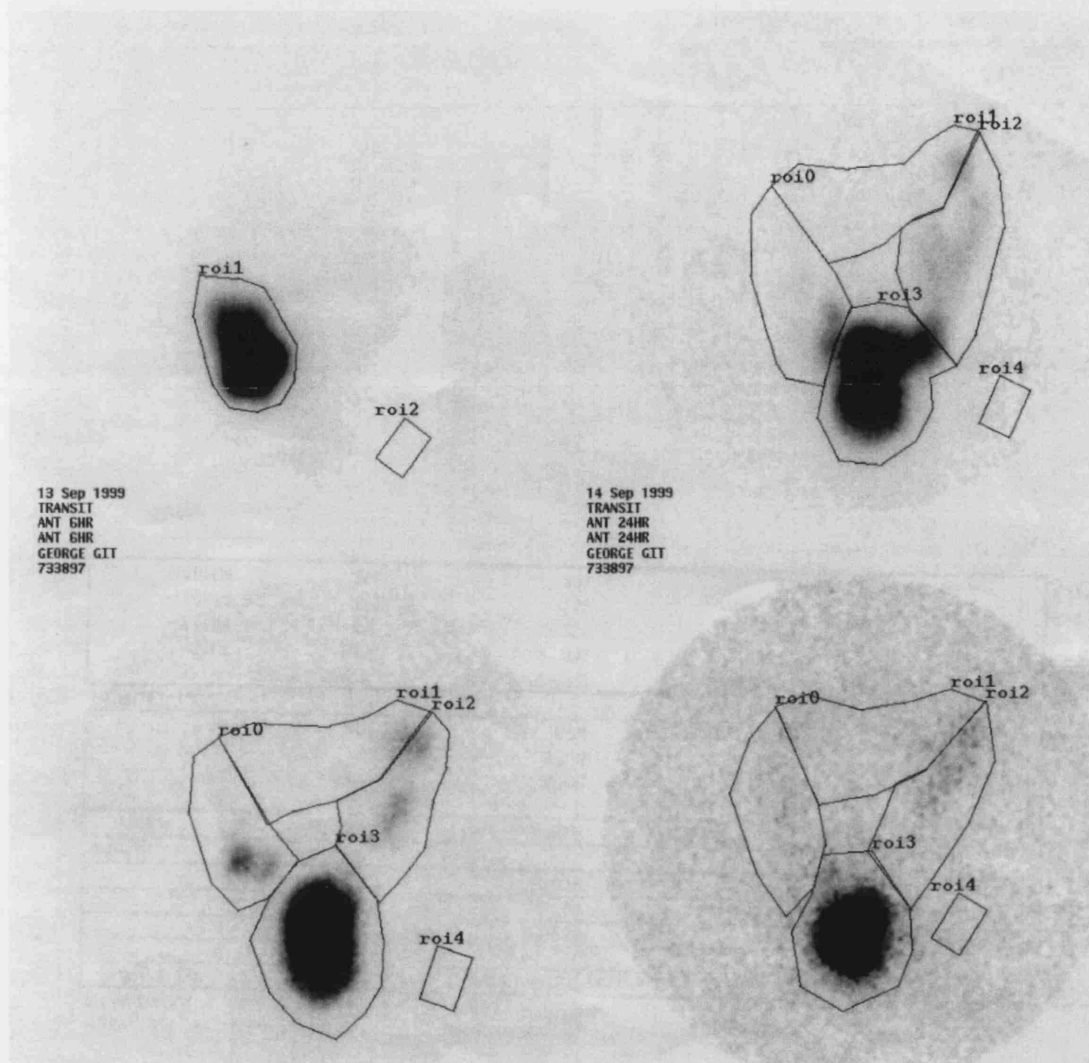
Example of a scintigraphic study showing functional faecal retention.
